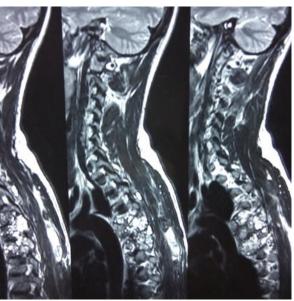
MRI dorsal spine sagittal cut T2 weighted images. Hyperintense lesion involving D4-D6
